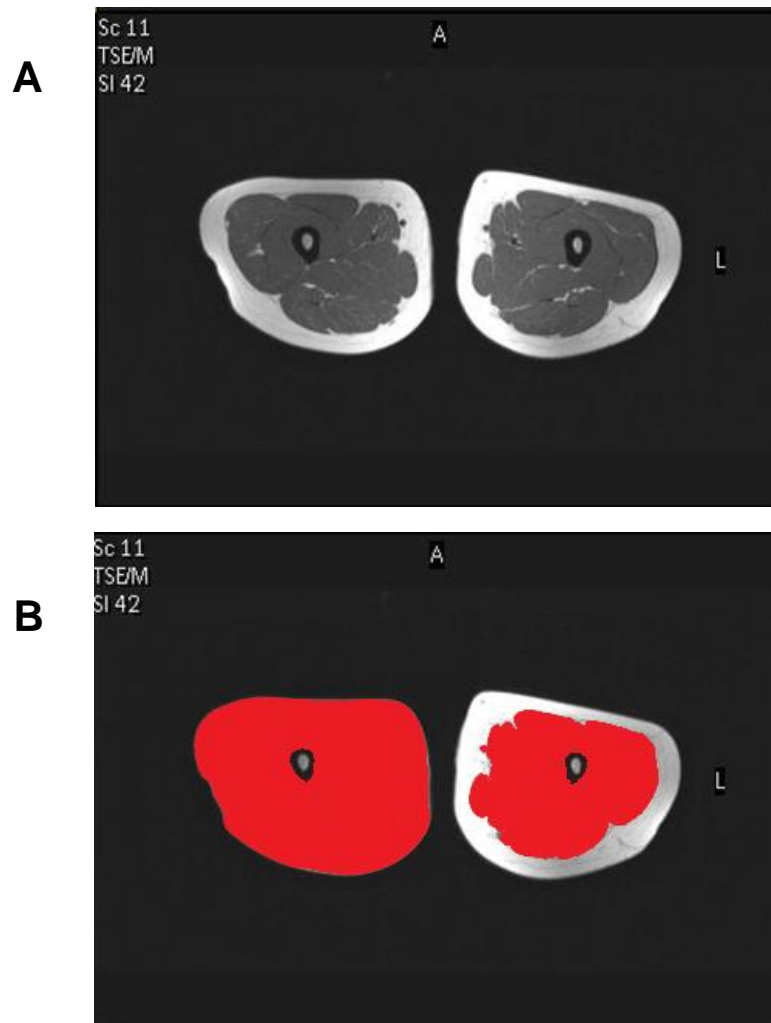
Example magnetic resonance images of the mid-thigh of a 14-year old female with cystic fibrosis. A: Cross-sectional area of mid-thigh as seen using magnetic resonance imaging software. B: The same image as (A), but with the shaded area in red on the left indicates the cross-sectional area used to calculate thigh volume (muscle and subcutaneous fat), with the shaded area on the right indicating the cross-sectional area used to calculate muscle volume. For both volumes, bone is excluded from cross-sectional area and subsequent calculation of thigh volume and muscle volume.
